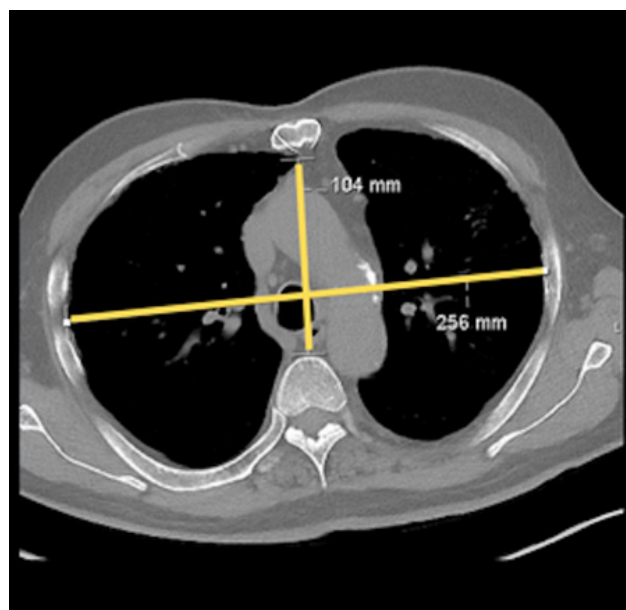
Measurement of the Haller index as the ratio of transverse to anteroposterior chest diameter on axial computed tomography.
